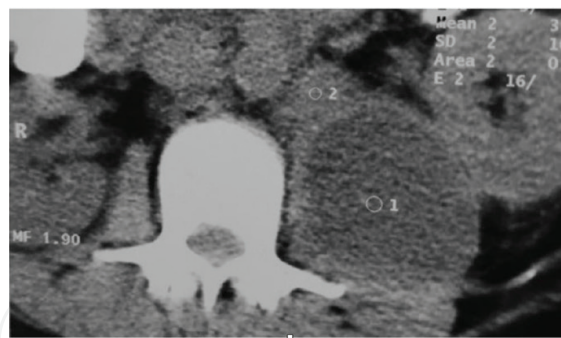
Axial CT revealing left psoas muscle abscess of 7×5 cm (1) and para-aortic lymph nodes (2).
